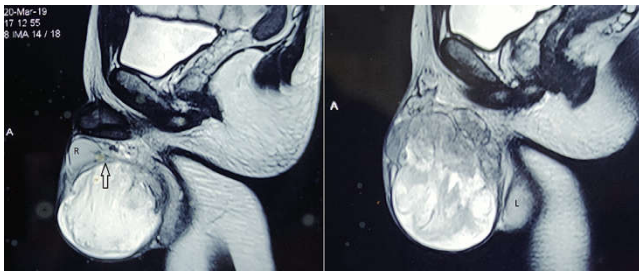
Preoperative MRI showing Left testis (L), Right Testis (R), and the right paratesticular lesion arising from the inferior end of spermatic cord (arrow). The lesion appear as well defined encapsulated, heterogeneous mass with solid and cystic components
